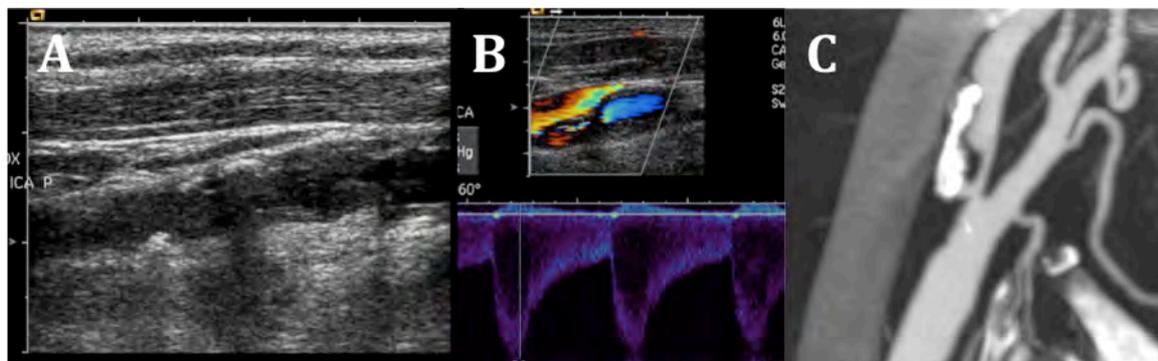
Assessment of carotid stenosis. A – grey scale image; B – Flow assessment with Doppler ultrasound mode; C - Computer tomography angiography
